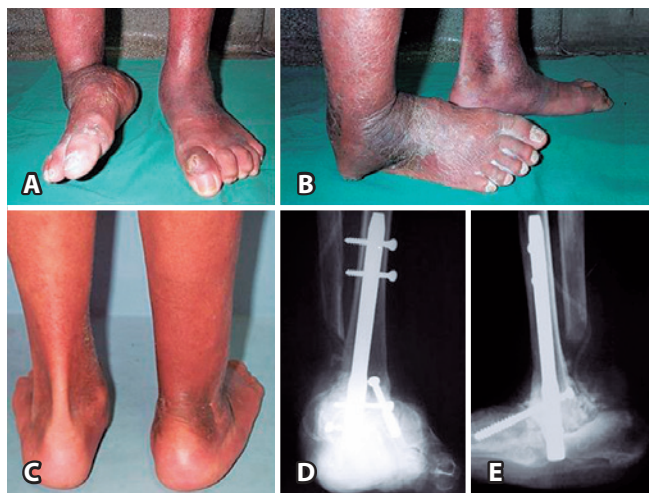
Photographs showing marked varus deformity and severe instability of the ankle, resulting in the lateral border of the right foot being used for support (5A) and pressure ulcer formation under the fibular malleolus (5B). Rear view of the lower limbs (5C) showing adequate alignment after tibiototalcalcaneal arthrodesis. Radiographic images show the correction obtained (5D and 5E).
